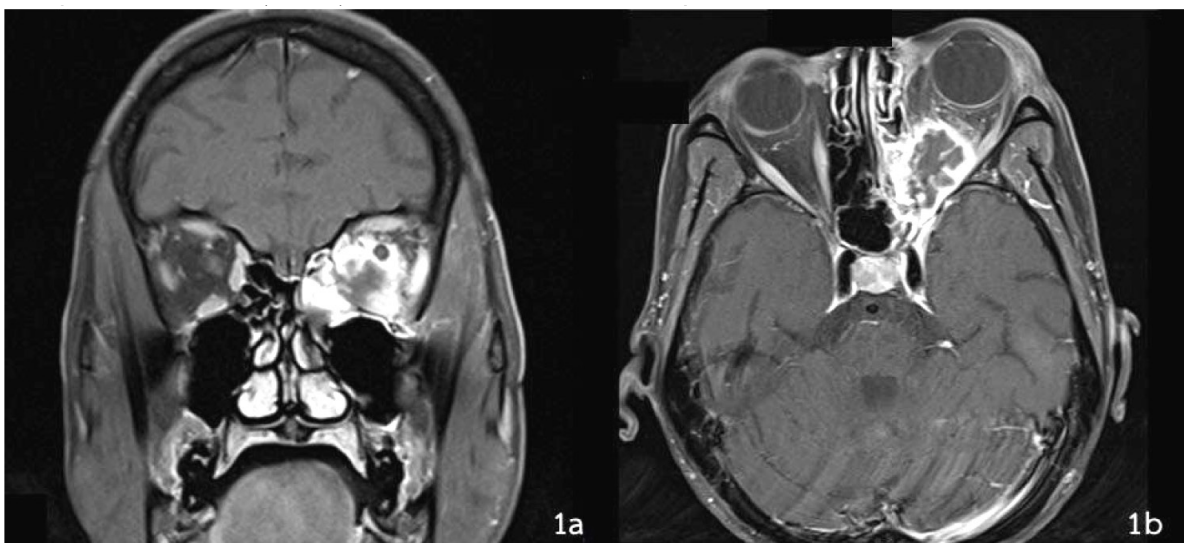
a: and b: Coronal and axial contrast-enhanced T1-weighted MR image shows an irregular peripheral contrast enhancing lesion in left orbit, involving both intra- and extraconal spaces, encasing left optic nerve, associated with thickened enhanced mucosa of nearby ethmoid sinus
